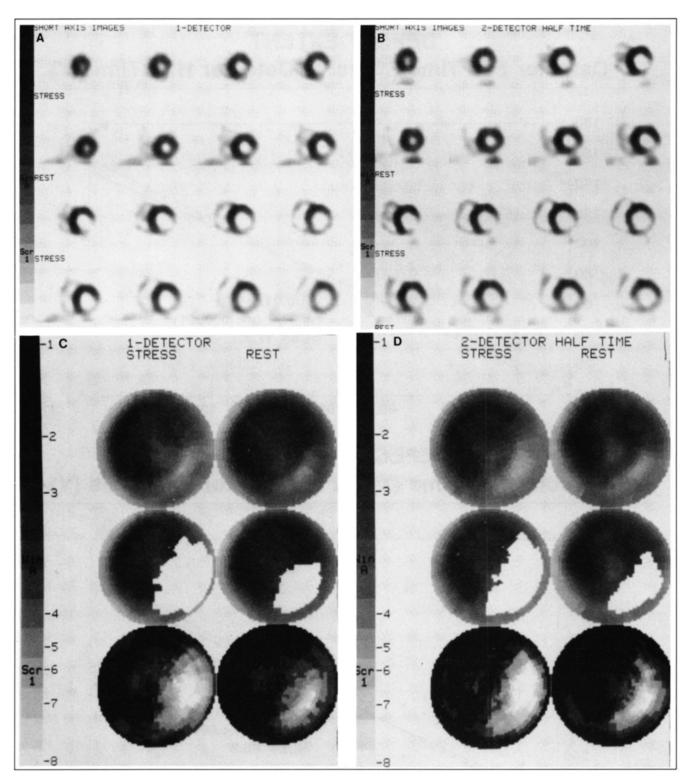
Patient with inferior myocardial infarction imaged using a single-detector camera and the two-detector camera with a half-time acquisition. (A) Short-axis stress/rest and tomograms with single-detector camera. (B) Short-axis stress/rest tomograms with two-detector camera, half-time acquisition. (C) Polar plots from a single-detector acquisition. The stress/rest raw polar plots (top row) demonstrate a very minimally reversible, essentially fixed, inferolateral perfusion defect. The extent plots (middle row) identify (whiten) all pixels significantly below gender-matched normal limits. The severity plots (bottom row) code abnormal pixels according to the number of standard deviations below normal limits (see gray scale on left hand border of image). (D) Polar plots from the two-detector camera using half the SPECT image acquisition time. Format same as (C).
